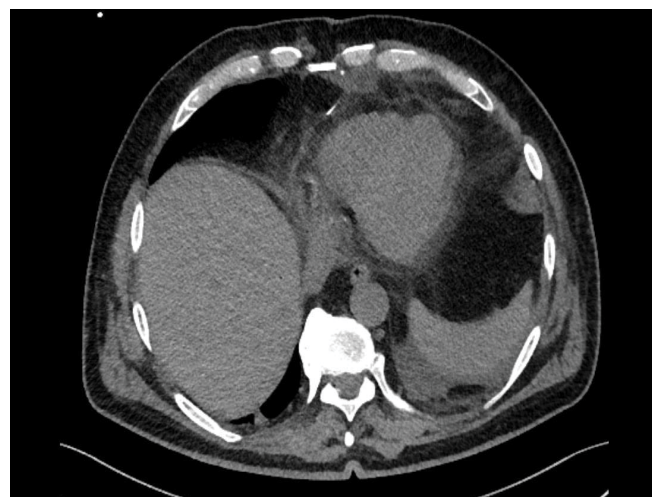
Chest computed tomography scan of a 67-year-old male patient after CABG + YurLeon; arrows indicate pericardial fat attached to the heart.
